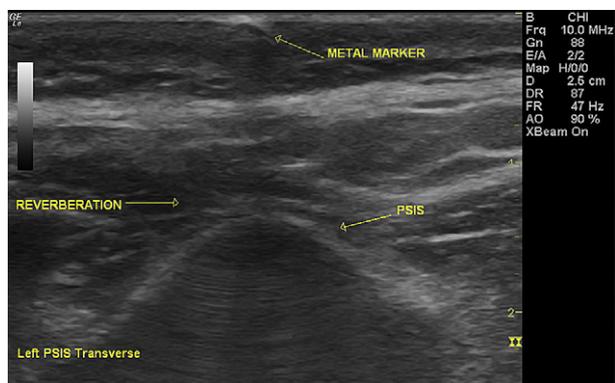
Ultrasound scan image of the LPSIS (transverse view). The faint line running through the centre of the image is reverberation artefact caused by echoes from the sonic wave bouncing back and forth between the transducer face and the metal marker used to identify the bony point. Transverse and longitudinal views were obtained using this technique to identify and confirm the distal aspect of the bony point, ensuring that the UV marks on the skin were over the point identified.
